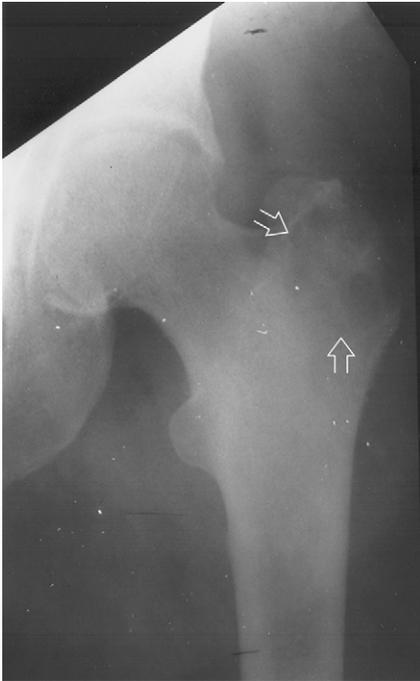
Cryptococcus* osteomyelitis. AP radiograph of the left hip shows a poorly defined round lucency in the greater trochanter of the femur (open arrows). There is no marginal sclerosis or periosteal new bone. (Case courtesy of Dr Vung Nguen, San Antonio, TX.)
